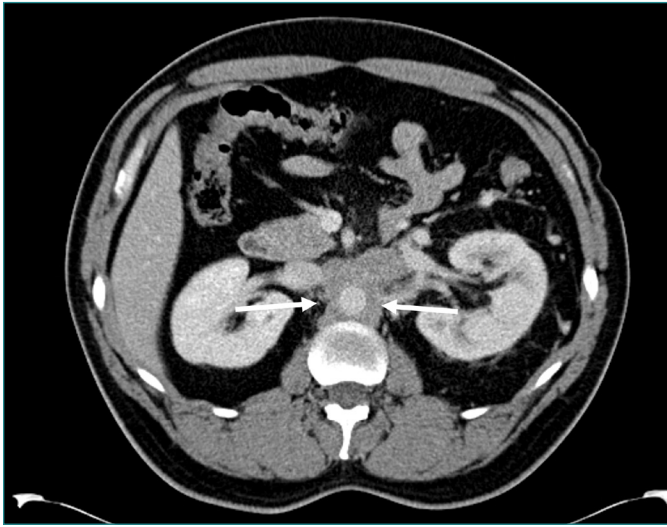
Axial CT with contrast showing maximal 2.5 cm soft tissue thickening encasing the aorta indicated between 2 white arrows.
